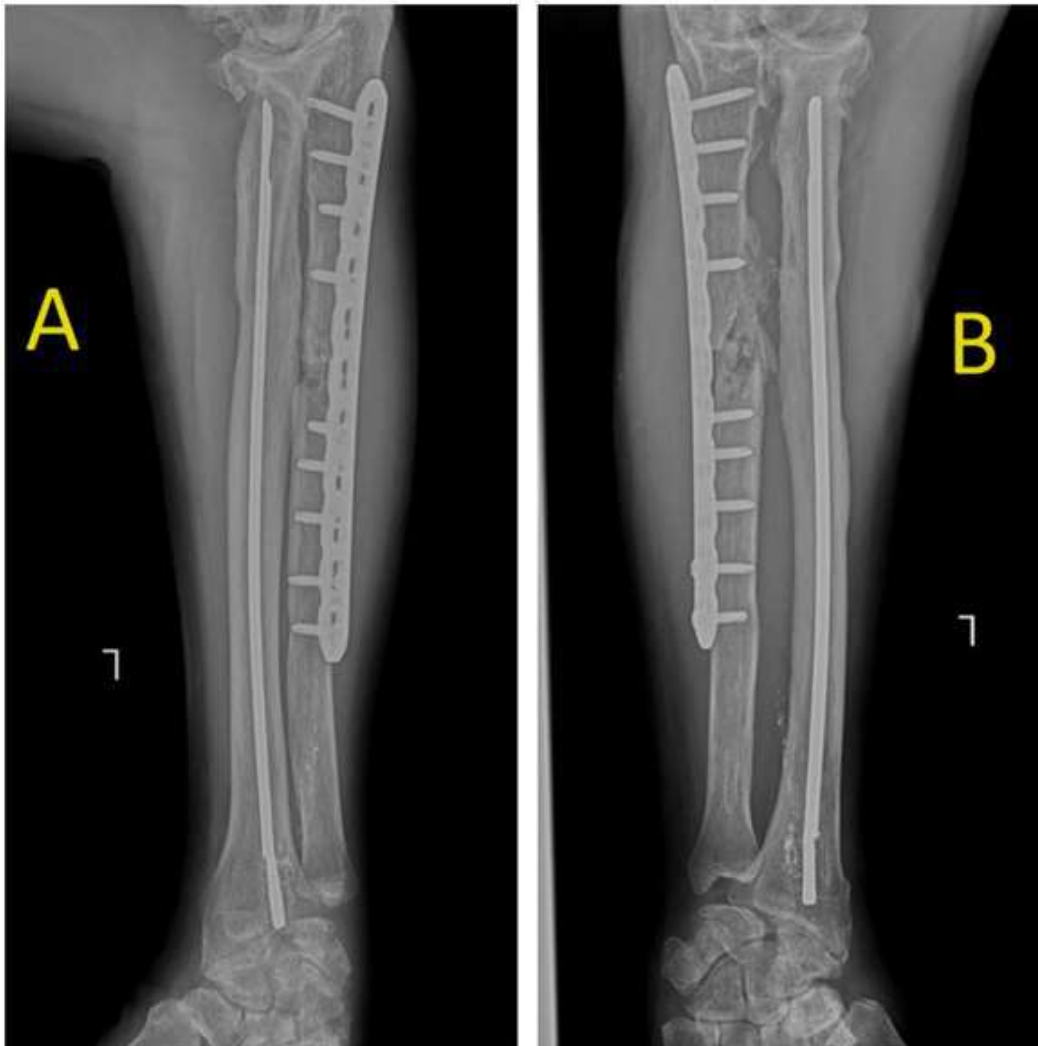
The anteroposterior (A) and lateral (B) X-rays of the forearm at three months follow up showing good progress and signs of union.
